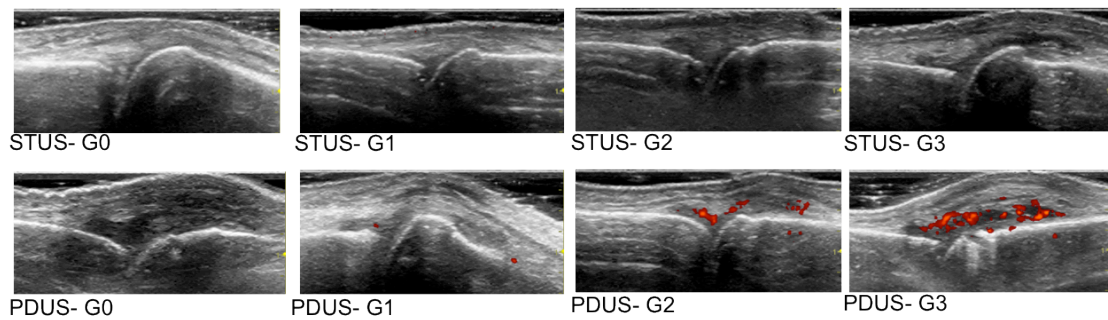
Ultrasound scan of longitudinal view of the 2nd left metacarpophalangeal joint
